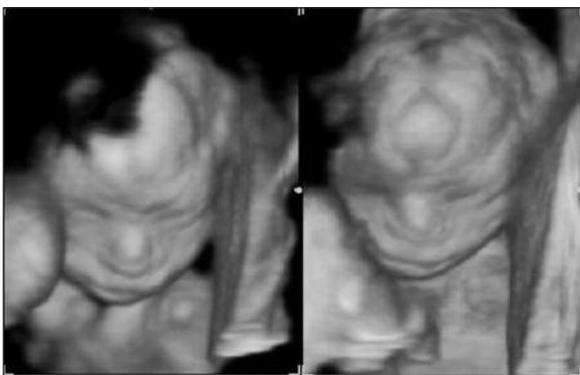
3D ultrasound image of fetal head from anterior aspect.
